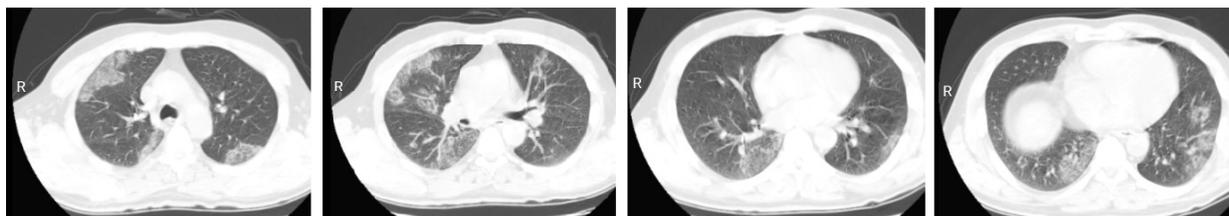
Chest CT scan of case 3 shows patchy peripheral ground glass opacities and consolidations in both lungs typical for COVID-19 involvements
